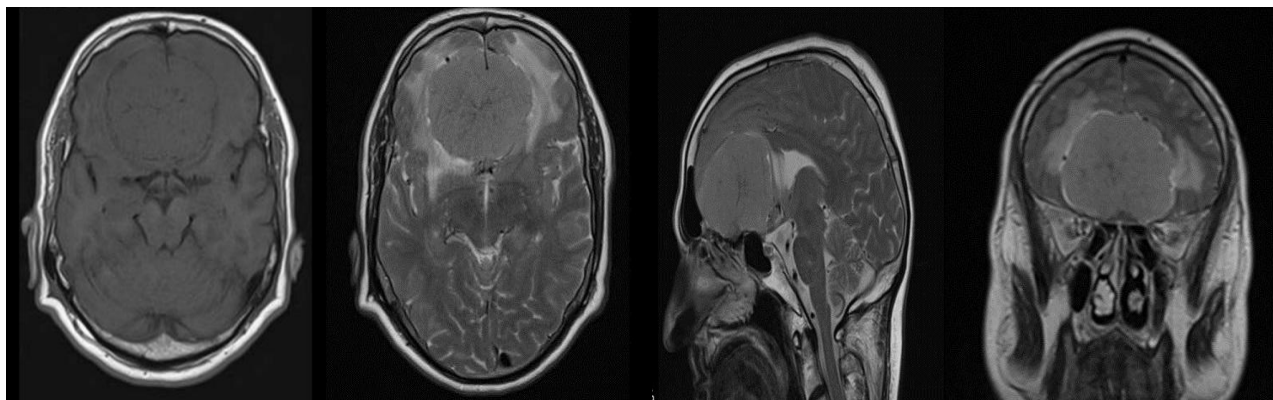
Axial T1W, T2W MRI, sagittal and coronal T2W MRI images showing a well-defined, large oval shaped mass, which is mainly isointense to grey matter on all the sequences, in the inferior aspect of the anterior cranial fossa and straddling the mid line. A rim of CSF intensity (C.S.F. cleft sign) is seen around the mass most notably on the T2W image.
